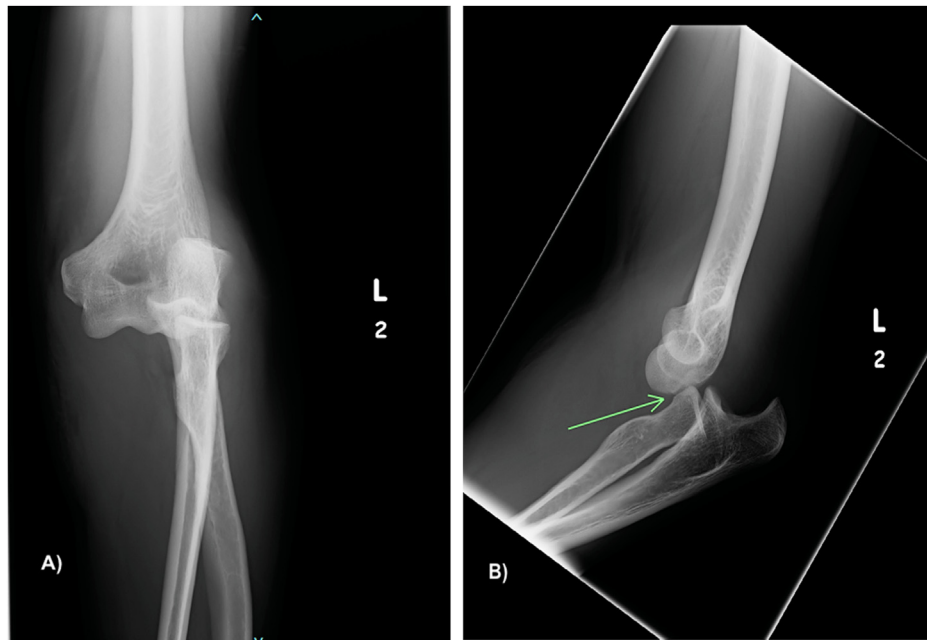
Anteroposterior radiograph of the left elbow joint showing elbow dislocation with far lateral dislocation of the proximal ulna and radial head A). Lateral view demonstrating a dislocation of the radiocapitellar and ulnohumeral joints with the radial head engaging with an impression (Arrow) over the posterior margin of the capitellum (Engaging Osborne-Cotterill lesion) B).
